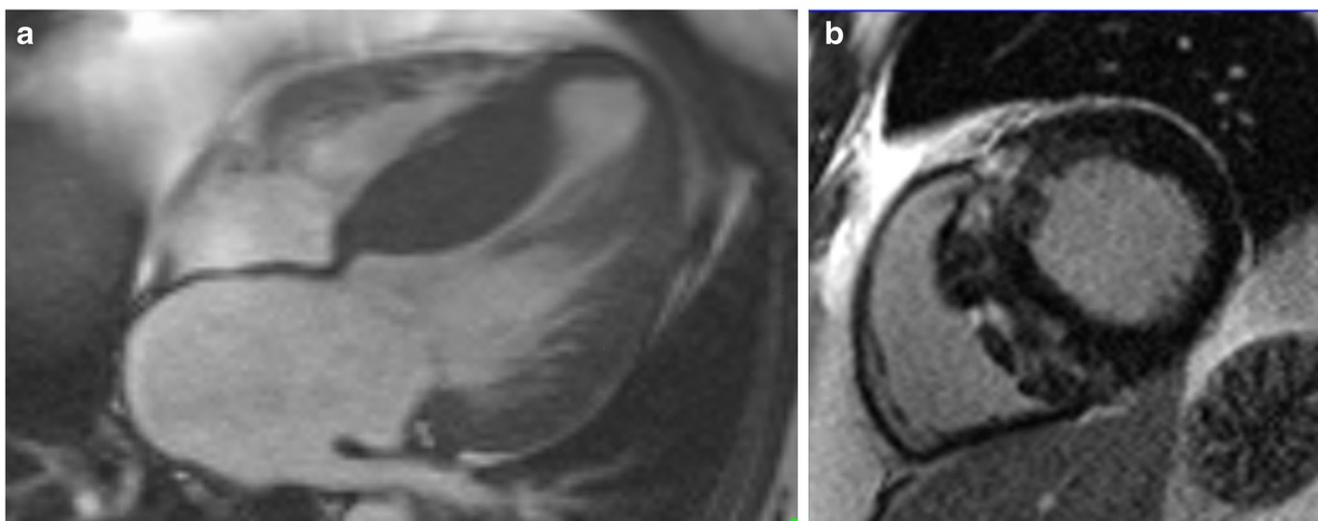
Asymmetric hypertrophy of the interventricular septum by cardiac MRI. a End-diastolic frame of the four-chamber cine showing the interventricular septum hypertrophy. b Short-axis late gadolinium
